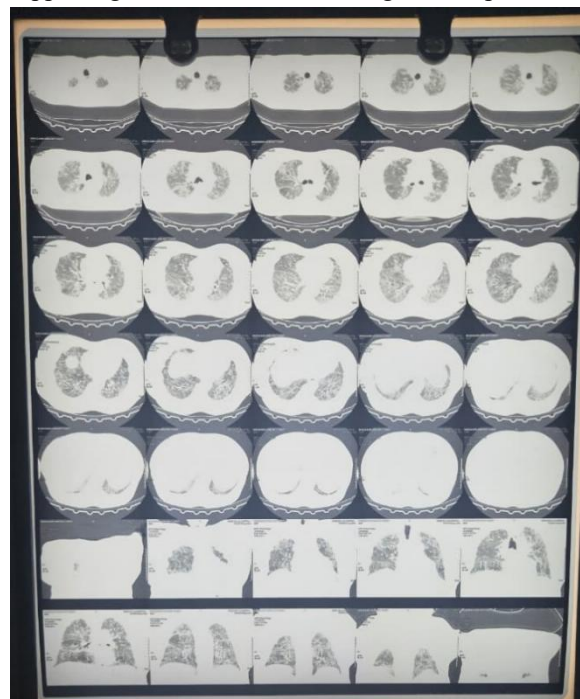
HRCT chest (axial mediastinal and coronal reconstructions) showing architectural distortion with bilateral lower lobe–predominant fibrosis and traction bronchiectasis, without significant focal consolidation, supporting a fibrotic interstitial lung disease pattern.
